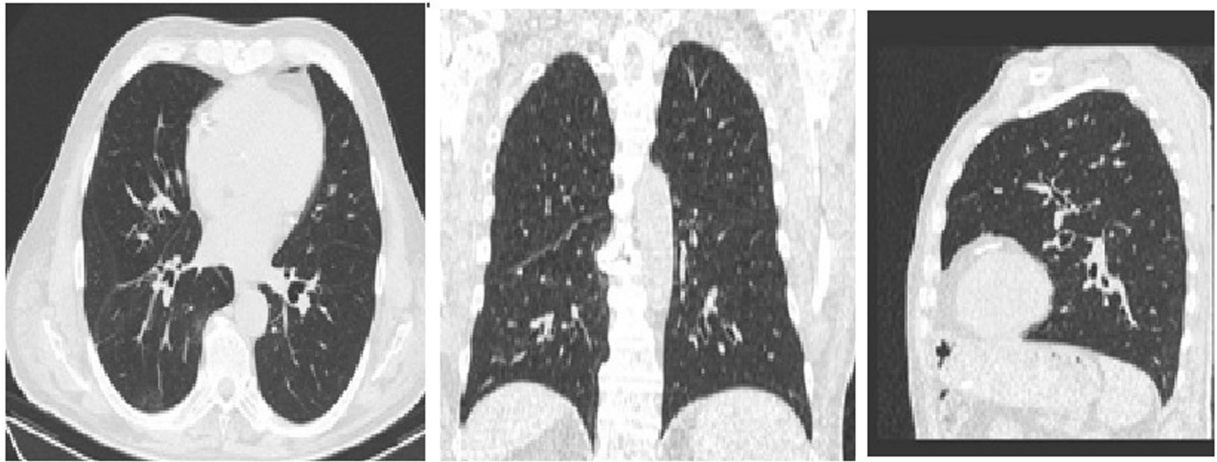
CT of lungs after plasty of the skull base defects causing liquorrhea (regression of inflammatory changes).
